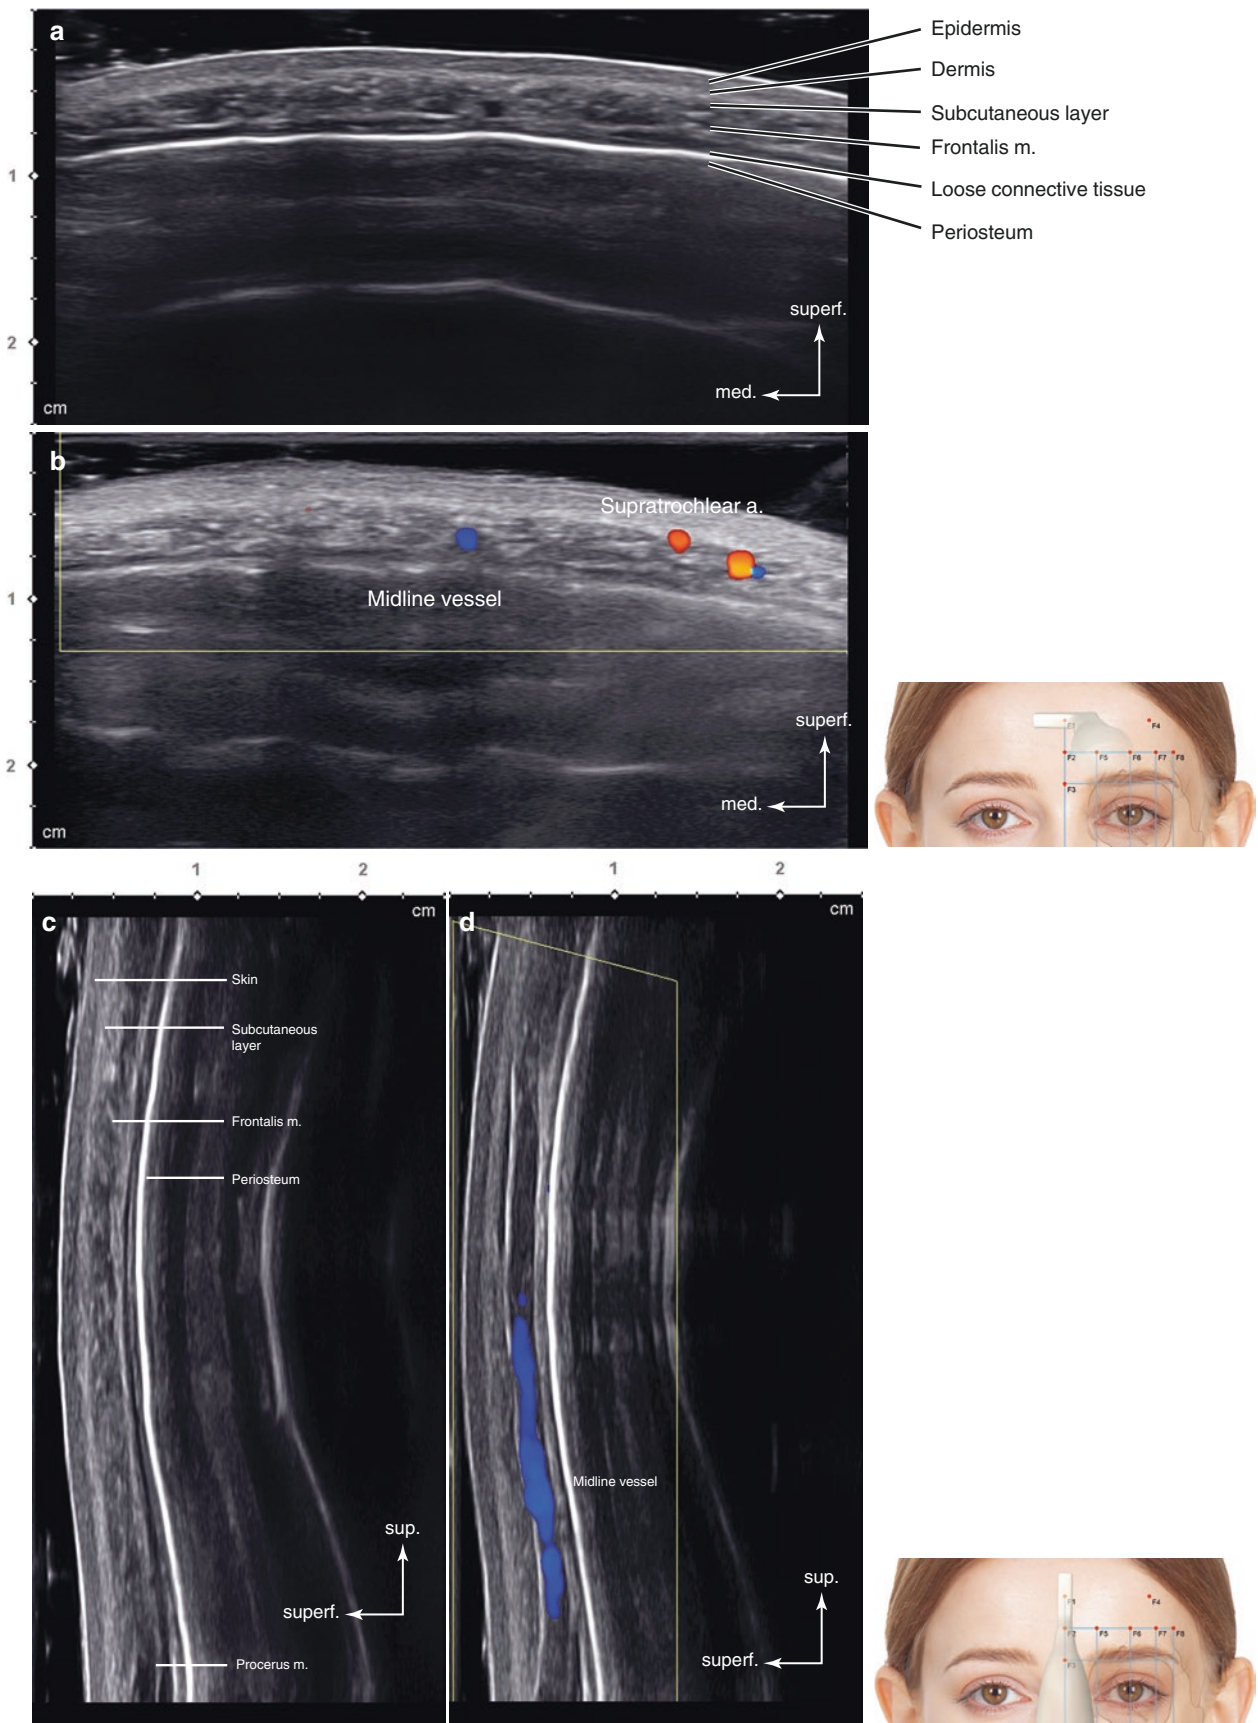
Ultrasonography on the metopion (F1). (a) B mode (transverse view, 15 MHz by linear transducer), (b) Doppler mode (transverse view, 15 MHz by linear transducer), (c) B mode (sagittal view, 15 MHz by linear transducer), and (d) Doppler mode (sagittal view, 15 MHz by linear transducer). (Published with kind permission of © Hee-Jin Kim 2020. All Rights Reserved)
